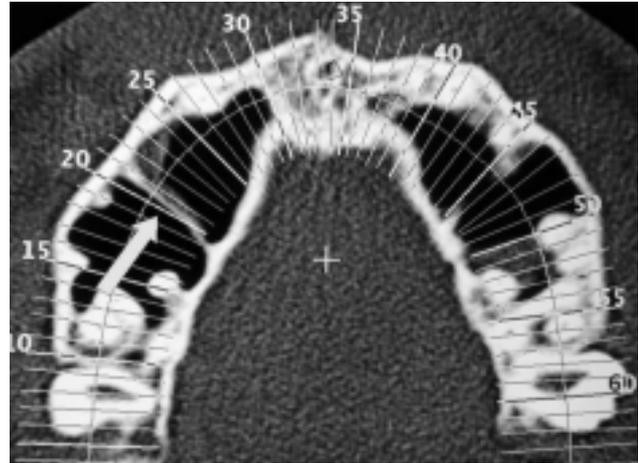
Axial CT scan showing a complete, thin septum on one side of the sinus (arrow).
